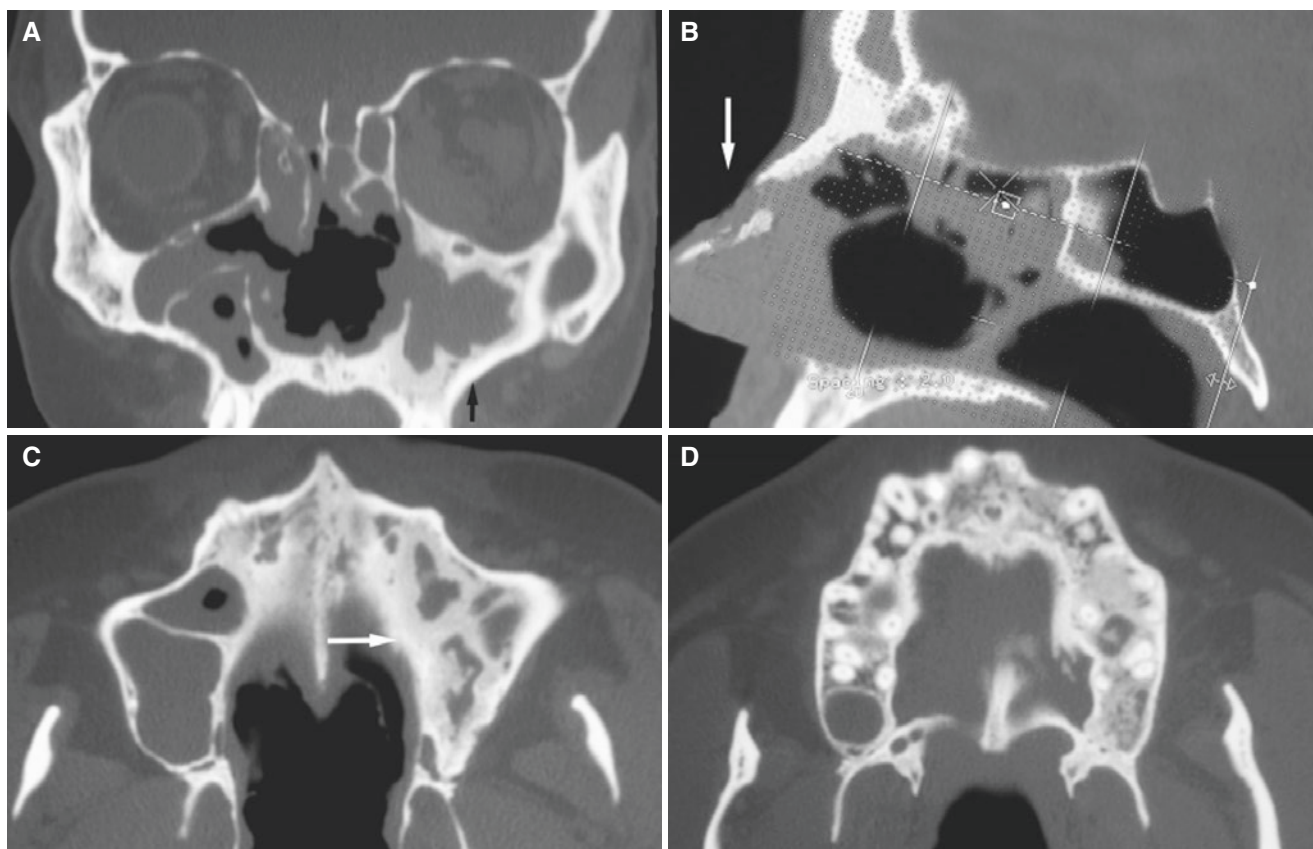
Granulomatosis with polyangiitis; 46-year-old male with long history of nonspecific sinus problems. Mucosal biopsy consistent with Wegener's granulomatosis. (A) Coronal CT image shows destruction of nasal cavity structures and chronic sinusitis; opacification and mucosal thickening of ethmoid cells and maxillary sinuses, with severe
